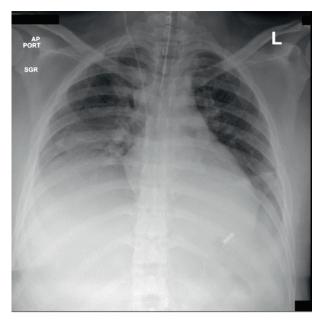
A chest X-ray after intubation and Rt internal jugular vein central line showing bilateral diaphragmatic elevation.
